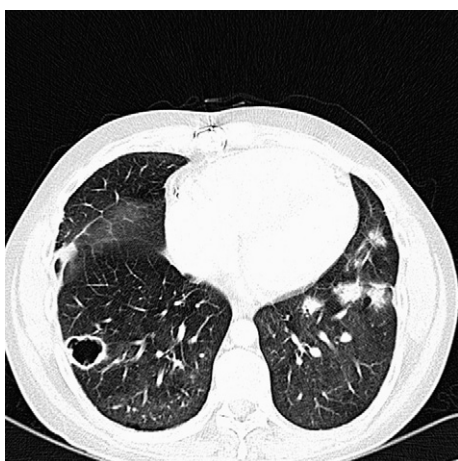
CT image confirming the presence of multiple cavities and nodules seen on CXR.
